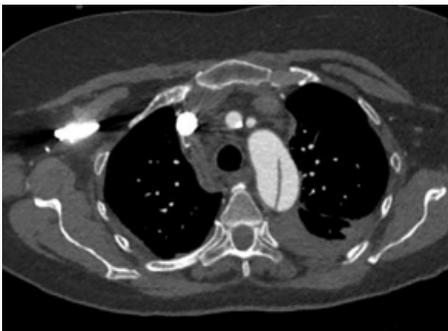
Chest CT angiography with presence of aortic dissection at the level of the aortic arch.
